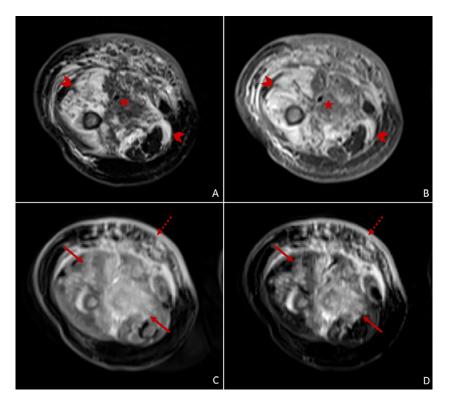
Magnetic resonance imaging of the right thigh. Axial T2-weighted image (A), axial T1-weighted image (B), axial postcontrast T1-weighted image with fat suppression (C), and axial postcontrast T1-weighted image with fat suppression subtraction image (D) show an infiltrative soft tissue lesion with poorly defined margins that involves all muscle compartments of the thigh, centred on the medial one. The central portion is isointense on the T2 and T1 weighted images (star, A and B), while the more infiltrative peripheral portion shows significant hyperintensity on the T2 and T1 weighted images (arrowheads, A and B). After contrast administration, the lesion demonstrates diffuse heterogeneous enhancement (arrows, C and D). There is also diffuse soft tissue edema with enhancing reticular stranding in the subcutaneous fat, mostly perpendicular to the skin surface, associated with enhancing cutaneous thickening (dashed arrow, C and D).
